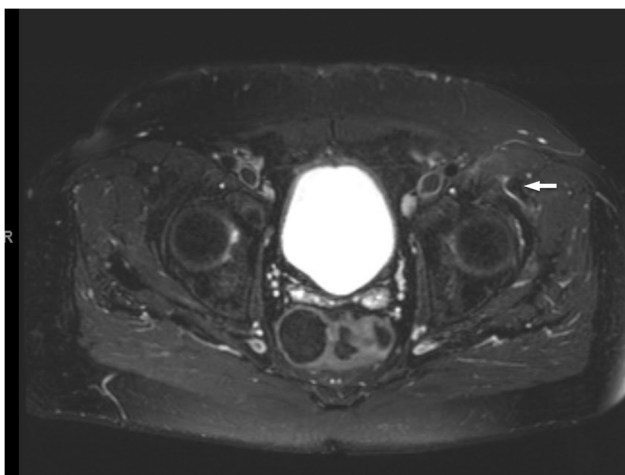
Axial magnetic resonance imaging cut showing the left rectus femoris tendon (direct head) avulsed from the anterior inferior iliac spine (arrow).
